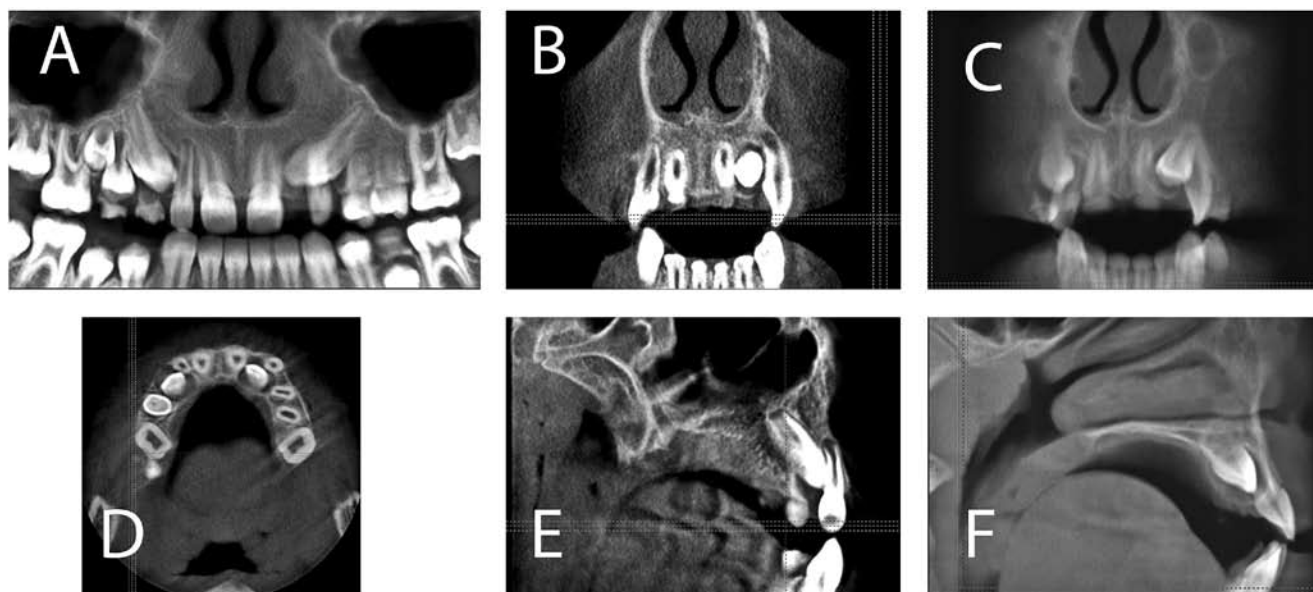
Radiographic examination results: a) orthopantomogram; b), c) frontal projections exported from CBCT scan; d) horizontal projection exported from CBCT scan; e), f) sagittal projections exported from CBCT scan
